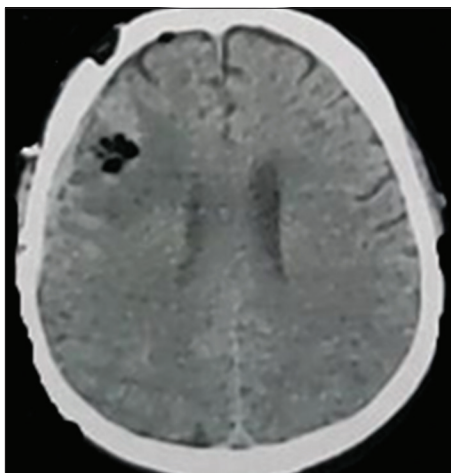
Three weeks after second resection did not reveal any evidence of residual or recurrent disease in computed tomography scan.
